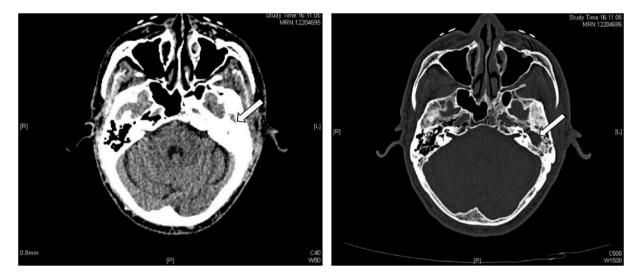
Brain CT scan Images. The above CT images of the head showed increased density of the left mastoid air chamber and bone destruction (marked by the white arrow) (day +2).
